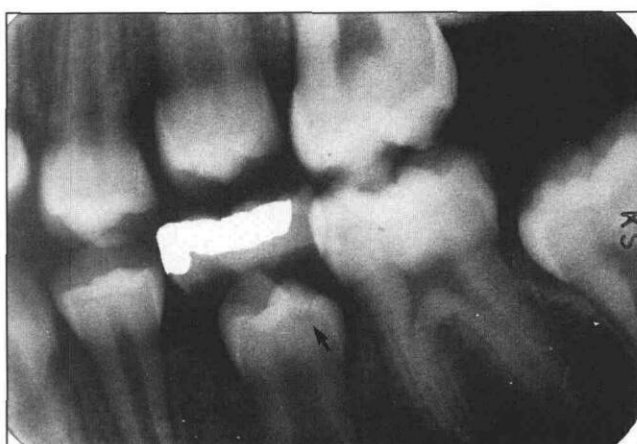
Bite-wing radiograph showing the lower left second premolar shortly before eruption. Notice the radiolucent area (arrow), and the recession of the pulp chamber close to the radiolucency.
